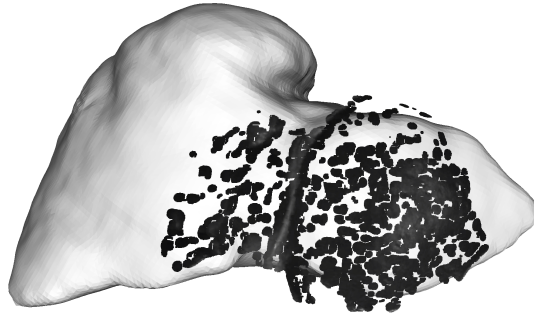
Intraoperative Alignment. The darker points in the foreground represent the surface reconstruction of the visible portion of the patient’s liver generated by the stereo reconstruction algorithm and subsequent postprocessing, as described in Section 3.3.2. The intensity of a given point matches the grayscale value of the corresponding pixel in the reference (right) image. The brighter surface model in the background is the preoperative *CT* scan of the same patient’s liver. The initial alignment of these two data sources was performed manually, in accordance with the description provided in Section 3.2.2.
